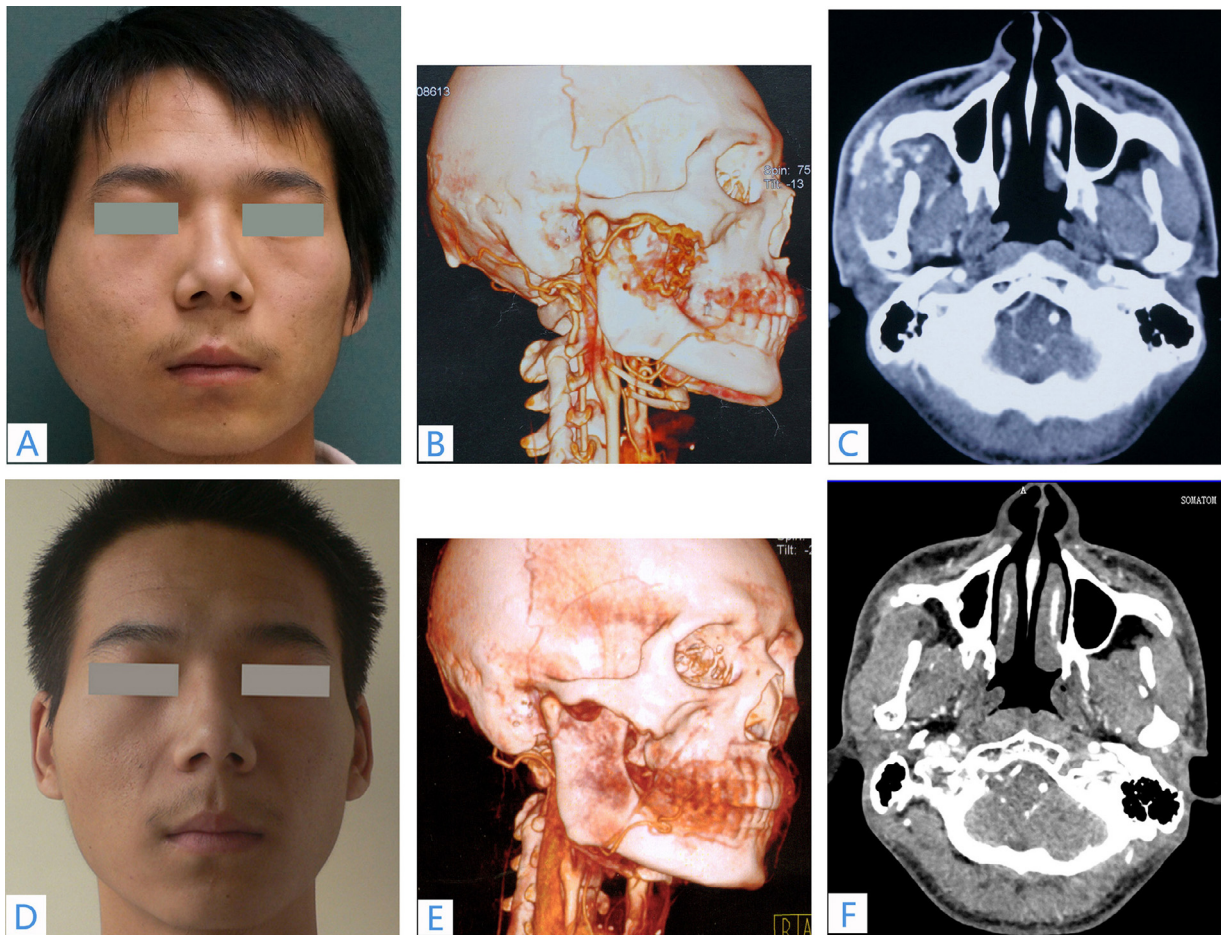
Arteriovenous malformation (AVM) in the right facial and zygomatic areas. A–C, Facial appearance, 3-dimensional computed tomography angiography (3-D CTA), and computed tomography (CT) scans before treatment. D–F, Facial appearance, 3-D CTA, and CT scans after treatment.
